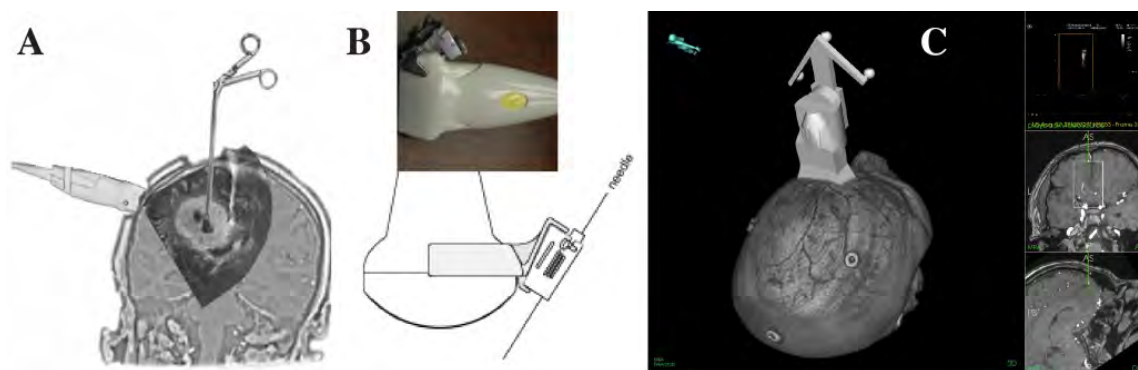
Ultrasound-based guidance: A) Freehand guidance: challenge to have the long axis of the instrument in the 2D ultrasound plane. B) Needle guides: an adapter mounted on the probe makes sure that the instrument is within the 2D ultrasound plane. C) Navigation: tracking technology and 3D data from modalities like CT, MR and ultrasound is used to guide relevant surgical instruments in place. Here an ultrasound probe is guided by MR during a freehand 3D ultrasound acquisition
